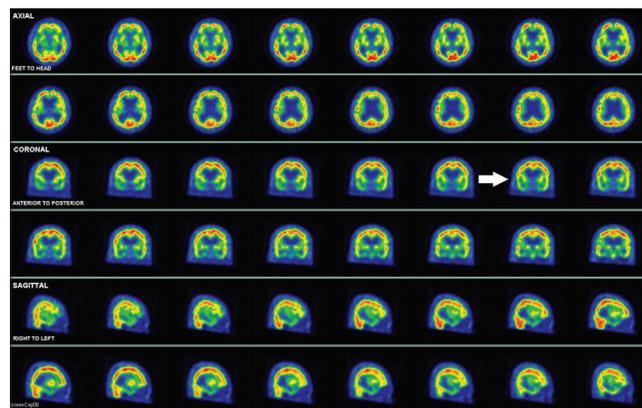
Single-photon emission computed tomogram showed the decrease of perfusion in bilateral inferior frontal gyri, bilateral anterior temporal regions, and right basal ganglion.
